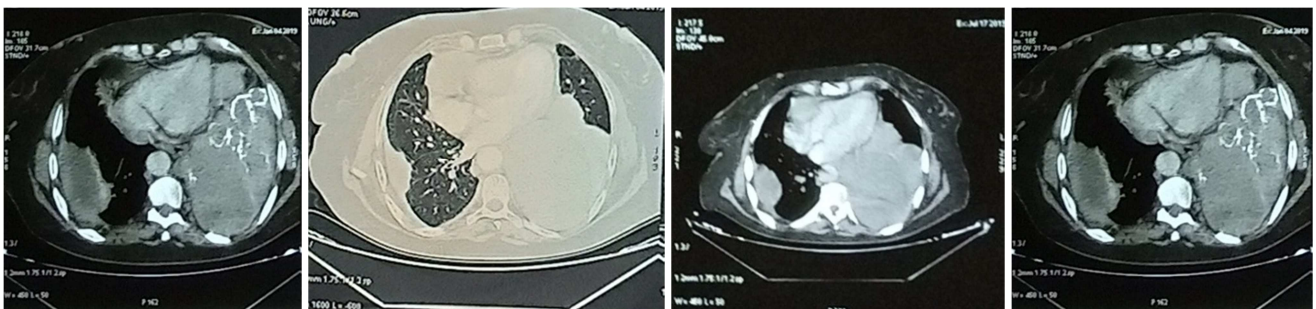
Thoracic transverse CT views.
